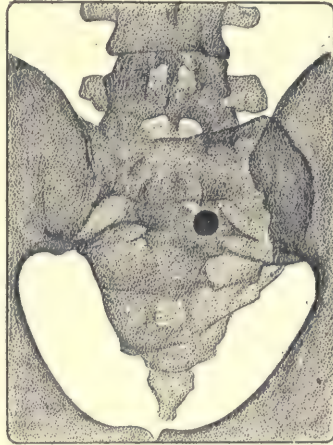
Tracing of a radiograph seen from behind. The shrapnel bullet of which the shadow is seen was 9 cm. from the dorsal skin. It was impossible, according to these data, to know with certainty whether it was lying in front of the sacrum, and at what level, or whether, on the contrary, it was included in the bone, a question which presented much interest from the operation point of view. (See Fig. 188.)
